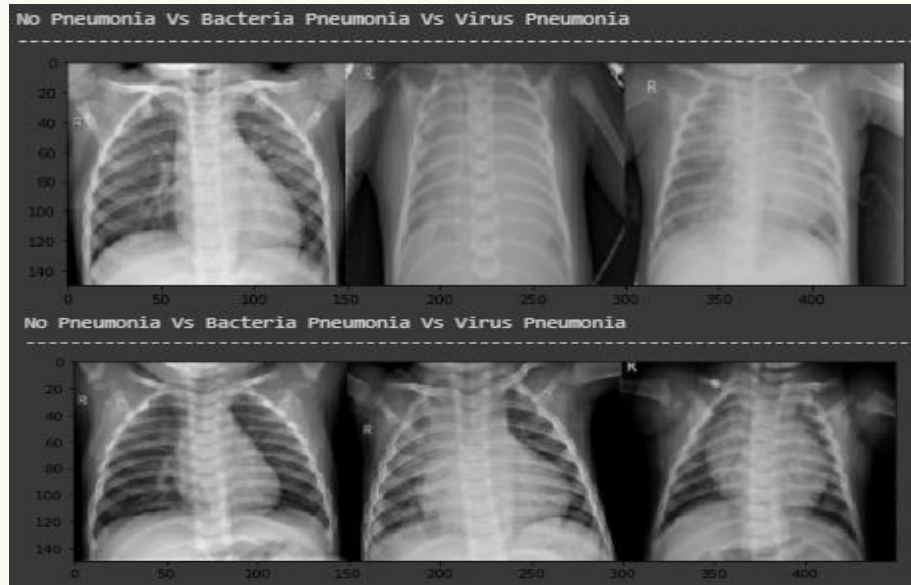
Normal X-Ray Results, Bacterial Pneumonia, And Viral Pneumonia
